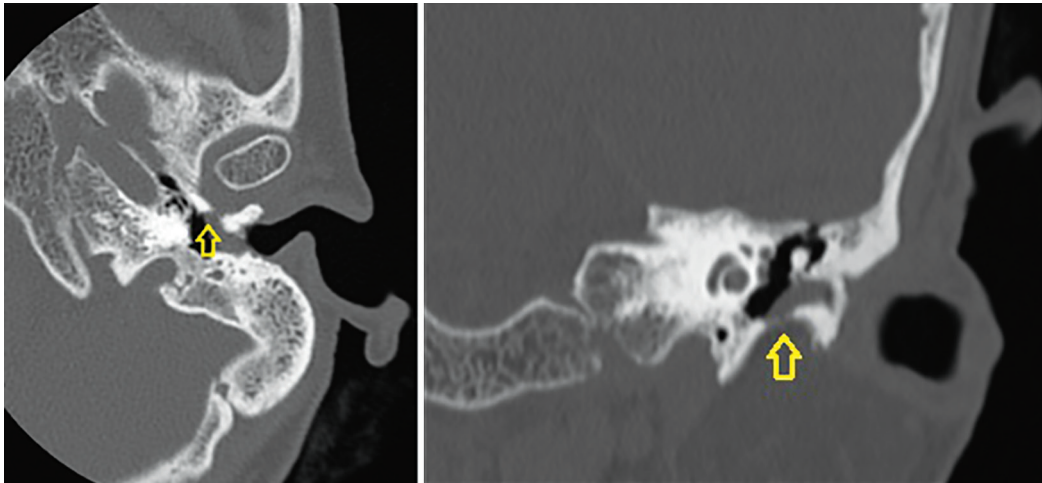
Noncontrast temporal bone CT. Yellow arrows show the bony defects on coronal and axial planes
